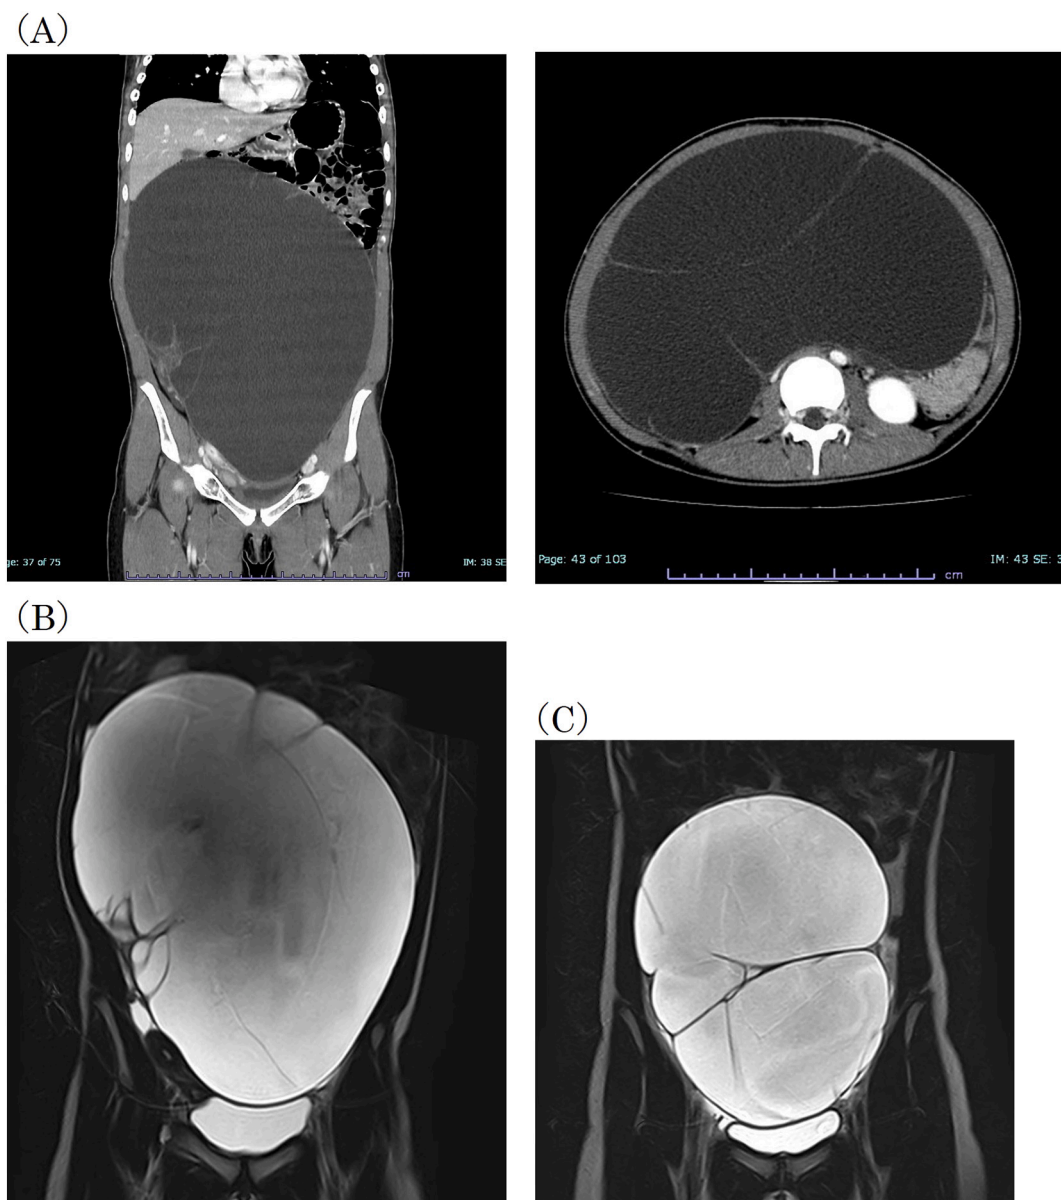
(A, B) At the time of initial diagnosis, CT and MRI showed a large polycystic mass occupying the abdominopelvic cavity. (C) When the mucinous cystadenoma recurred, CT and MRI revealed a polycystic mass in the abdominopelvic cavity. CT: computed tomography, MRI: magnetic resonance imaging.
